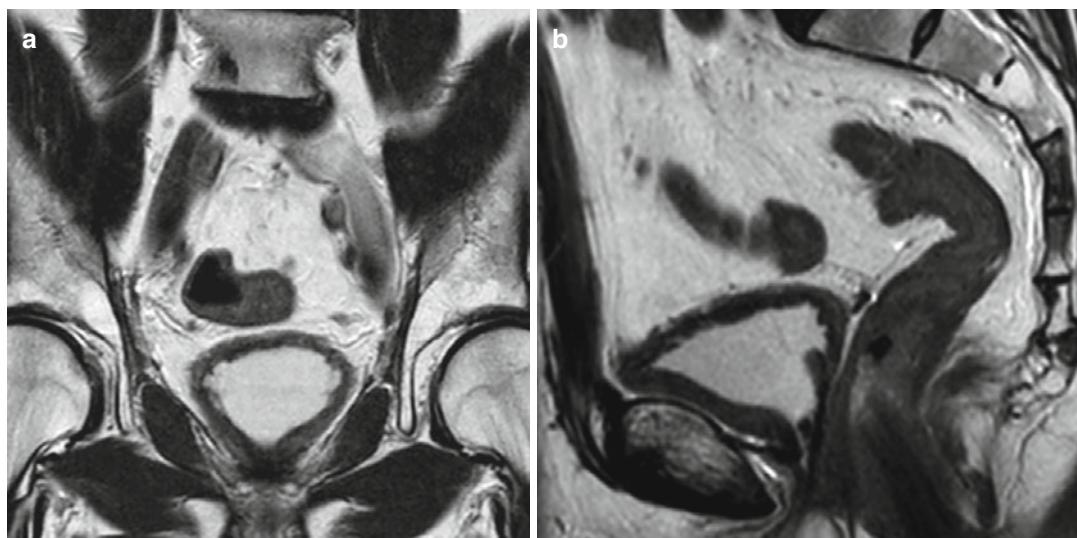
Appearances following radical retropubic prostatectomy. (a) Coronal and (b) sagittal T2-weighted images through the prostate bed show the caudal decent of the bladder. The
